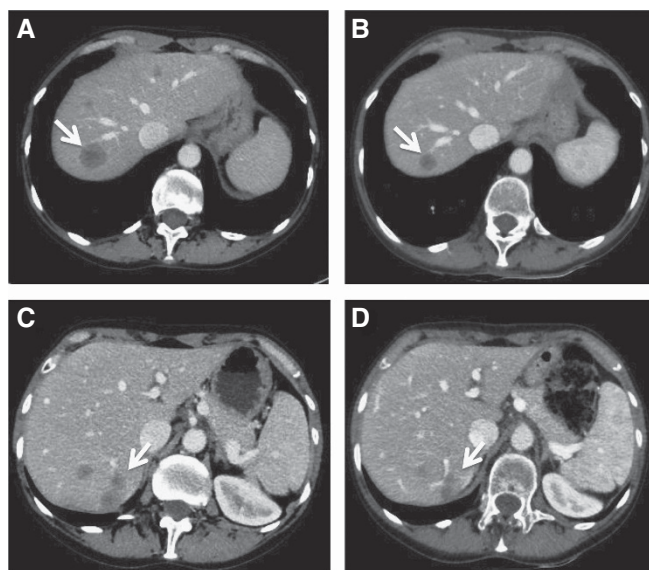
Computed tomography (CT) scans showing the objective tumour response to entrectinib. The baseline abdominal CT scan of March 2015 demonstrated liver involvement with the two largest lesions both in hepatic segment VII, measuring 27 and 33 mm in longest diameter, respectively (A, C arrows). At the first-response assessment, in April 2015, 4 weeks after the initiation of treatment, CT showed a RECIST partial response with an overall decrease in the sum of the target lesions of 38%, and lesions in segment VII displaying longest diameters of 15 and 22 mm (B, D arrows).
